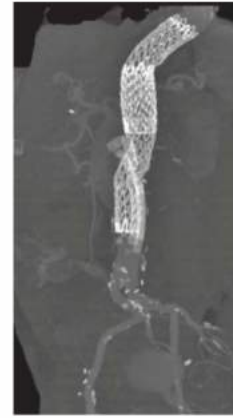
• Completion CTA showing exclusion of aneurysm and periscope stents in excellent position, perfusing SMA and right renal artery.
